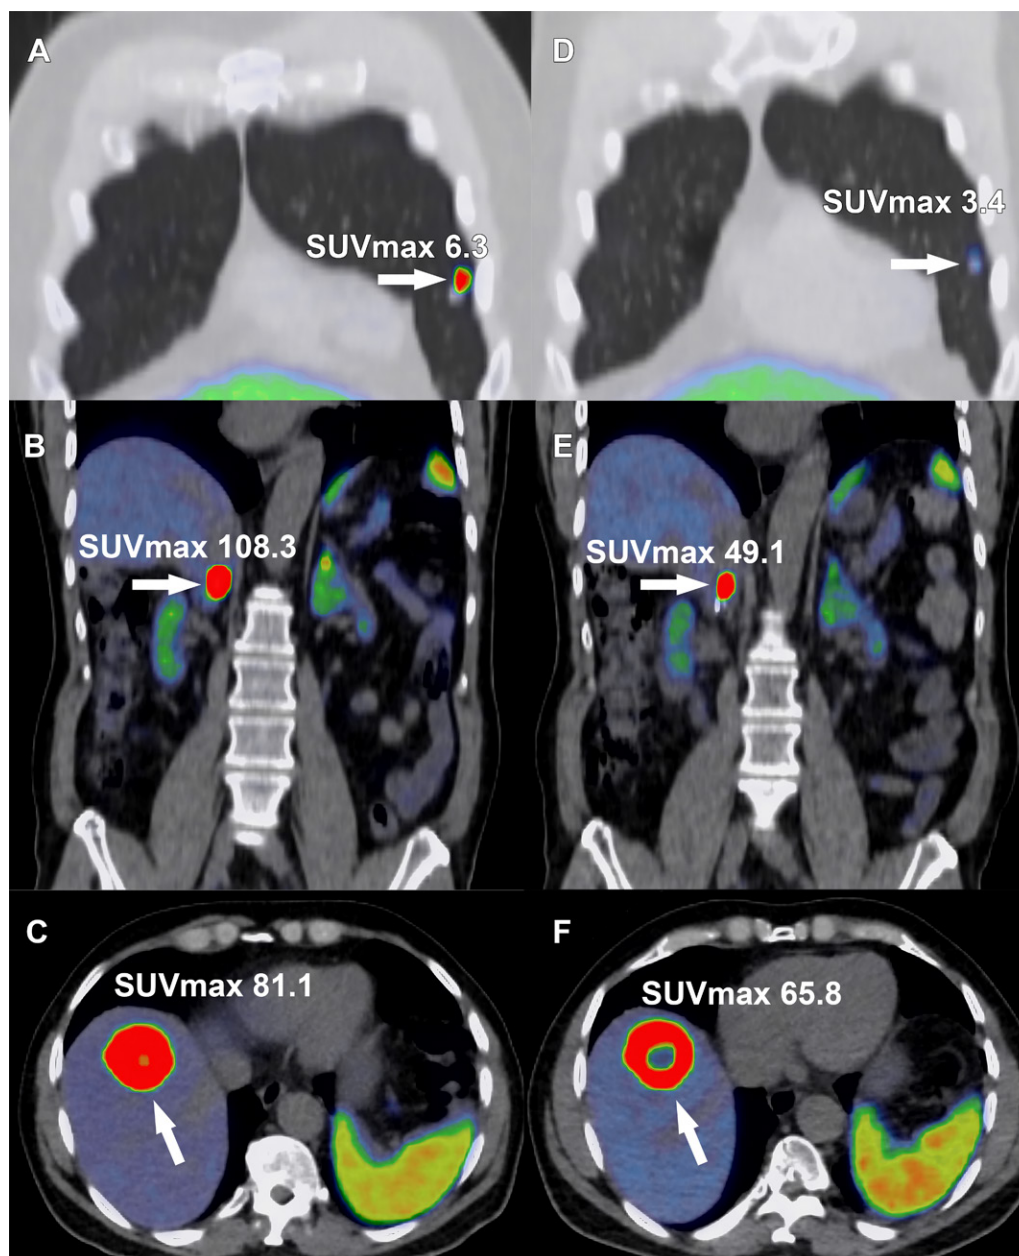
Images in a 68-year-old man with metastatic pheochromocytoma treated with four cycles of lutetium ^{177}Lu tetraazacyclododecane tetraacetic acid octreotate (DOTATATE). A right adrenal pheochromocytoma was resected 2 years previously, with subsequent development of hepatic, osseous, and pulmonary metastasis and inferior vena cava (IVC) tumor thrombus. Selected gallium ^{68}Ga DOTATATE PET/CT fusion images show a DOTATATE-avid (A) pulmonary metastasis (arrow), (B) IVC tumor thrombus (arrow), and (C) hepatic metastasis (arrow). Following completion of off-label ^{177}Lu -DOTATATE therapy, (D) the pulmonary metastases decreased in radiotracer uptake level, (E) IVC tumor thrombus, and (F) hepatic metastasis decreased in radiotracer uptake level. Central photopenia indicating tumor necrosis increased with the treated hepatic metastasis (E, arrow). SUV_{max} = maximum standardized uptake volume.
